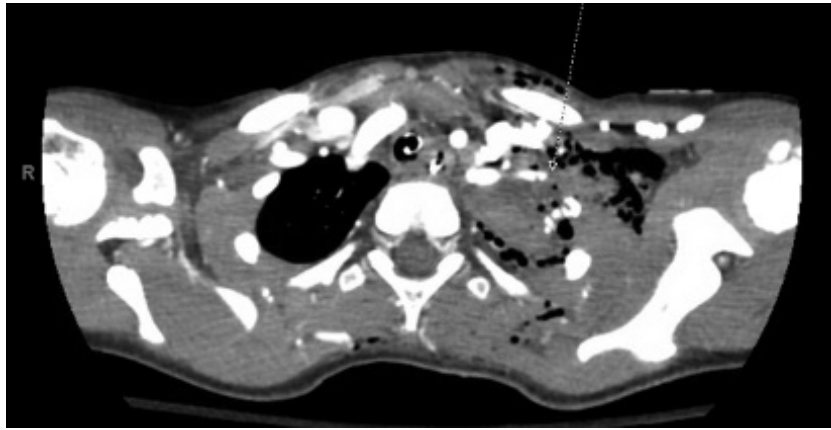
Six-year-old male gunshot wound to left shoulder, hemo/pneumothorax s/p chest tube placement. CT angiogram of the chest and neck revealed complete occlusion of the subclavian artery with distal reconstitution at axillary artery.
